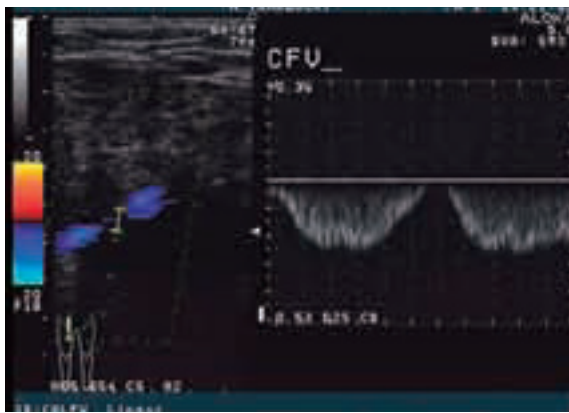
Respiration-related changes in blood flow through the common femoral vein (CFV). *Left*, sampling points for the pulse Doppler method. *Right*, flow velocity pattern using the pulse Doppler method. The flow velocity decreases during inspiration and increases during expiration
